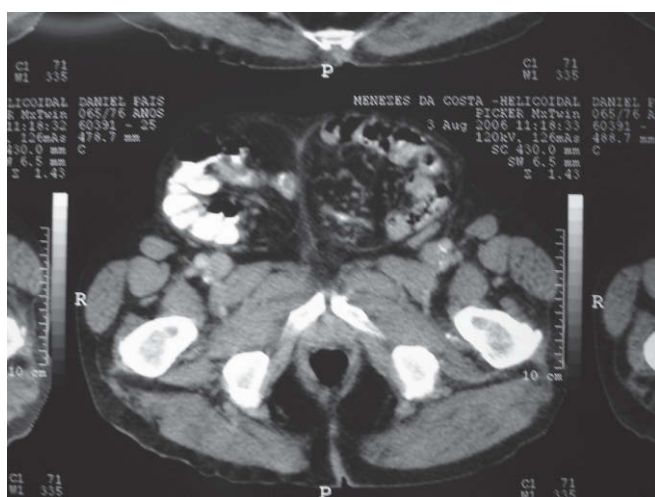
Magnetic Resonance Image of Hernias.
